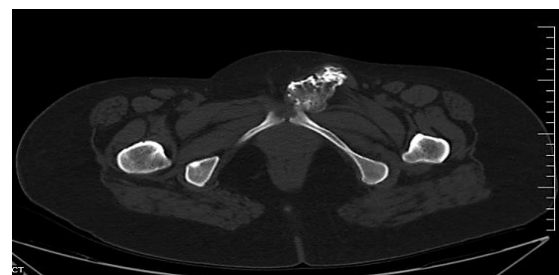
Computed tomography (CT) scan of the pelvis showing the pedunculated growth arising from the pubic tubercle
